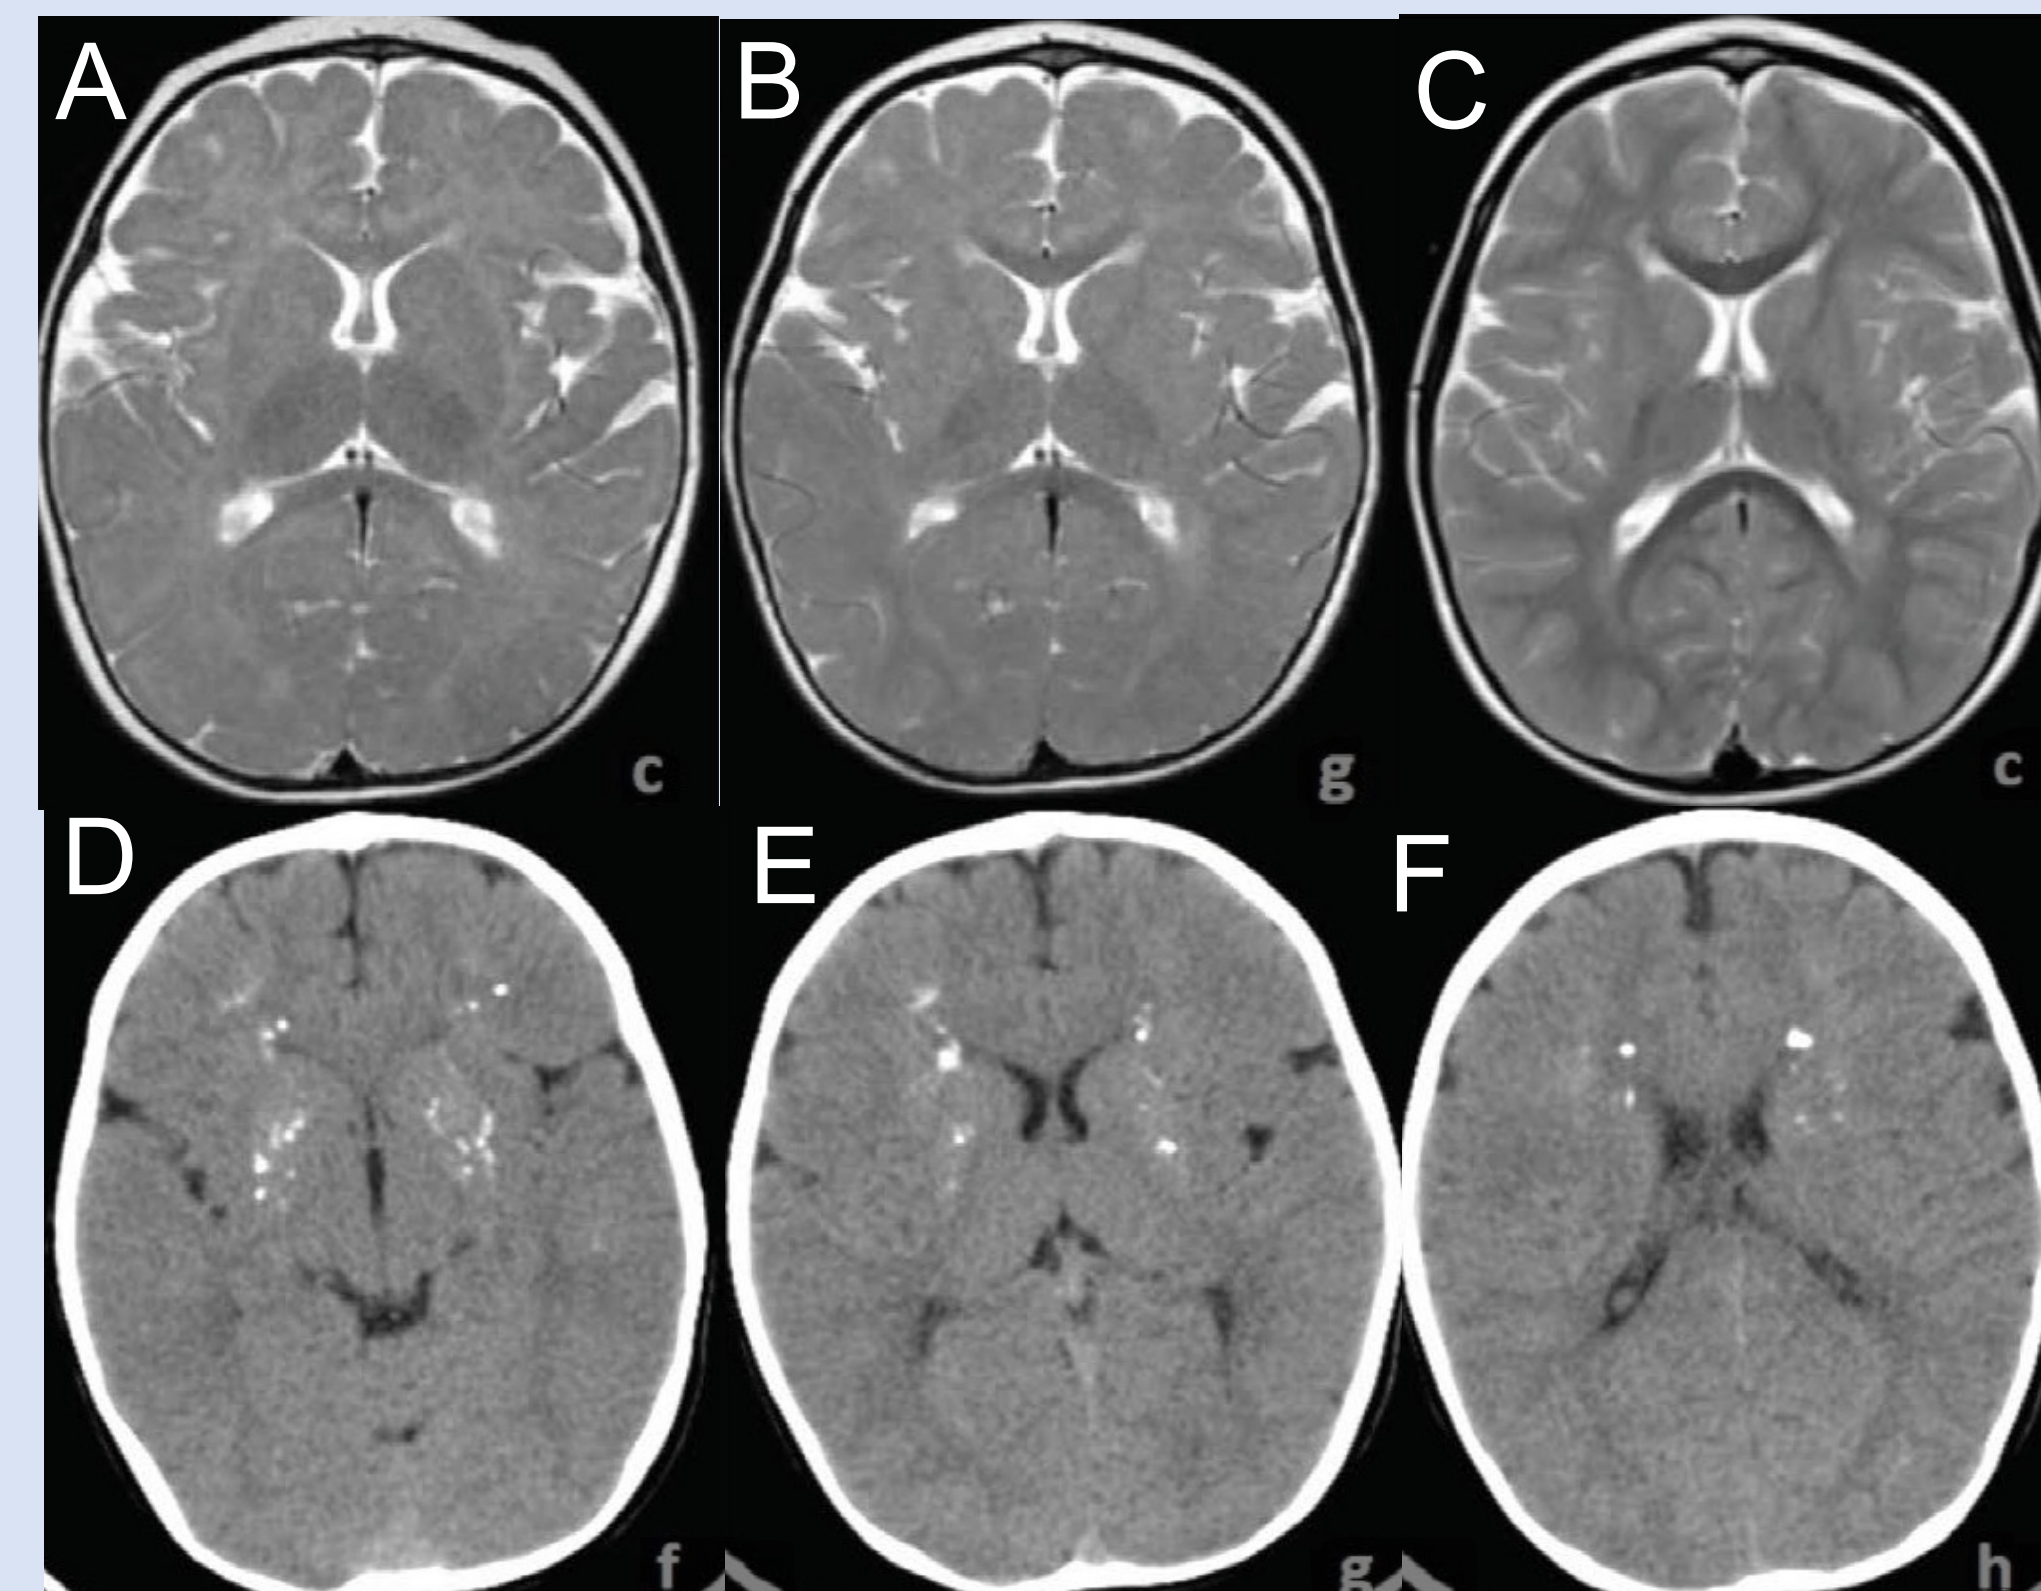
MR imaging of the patient who was found to have a homozygous mutation in the TREX1 gene. T2 axial image at 8 months shows hypomyelination (A), T2 axial image at 20 months shows increased myelination, (B), no calcification (C). Brain CT images at the age of 4 show calcifications in bilateral basal ganglia and white matter (D,E,F).
